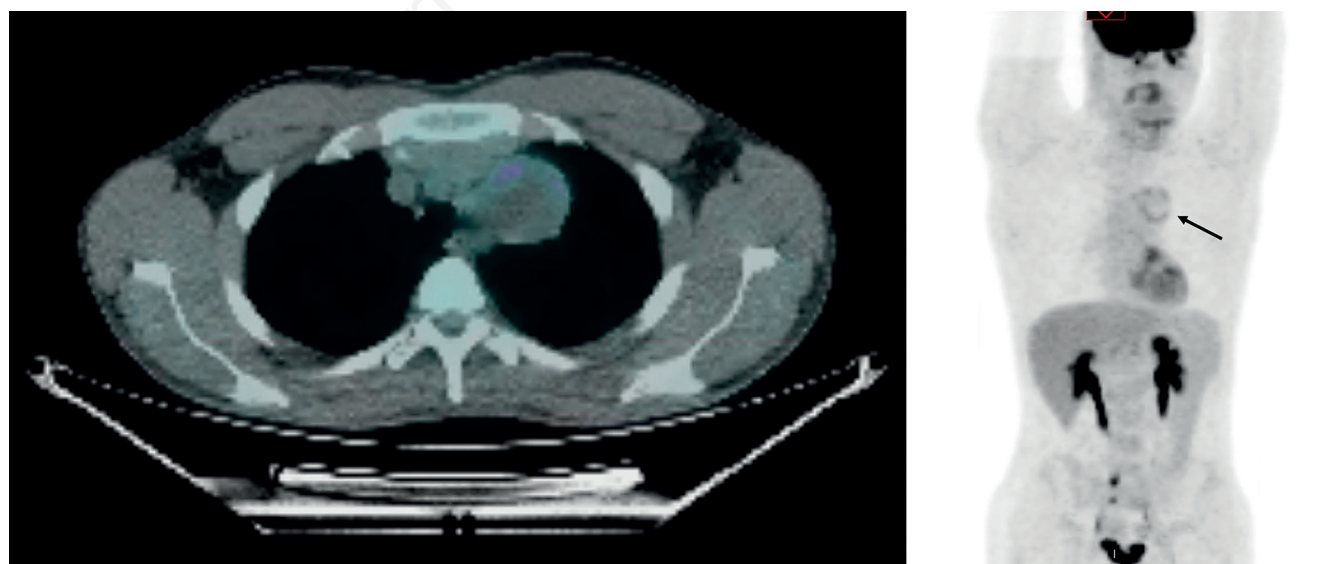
Positron emission tomography demonstrating a slight standardized uptake value (SUV) of 3 along the wall of the mass, with a hypometabolic central portion.
